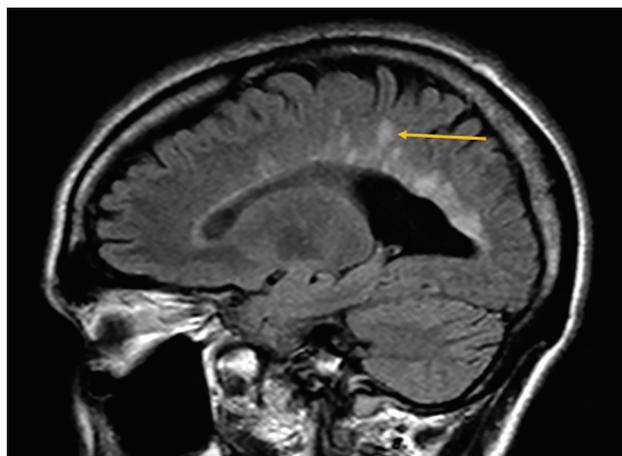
Sagittal T2 FLAIR image reveals ‘Dawson’s fingers’ (arrow), which are demyelinating plaques at callosal-septal location, running at right angles along medullary veins, due to perivenular inflammation
